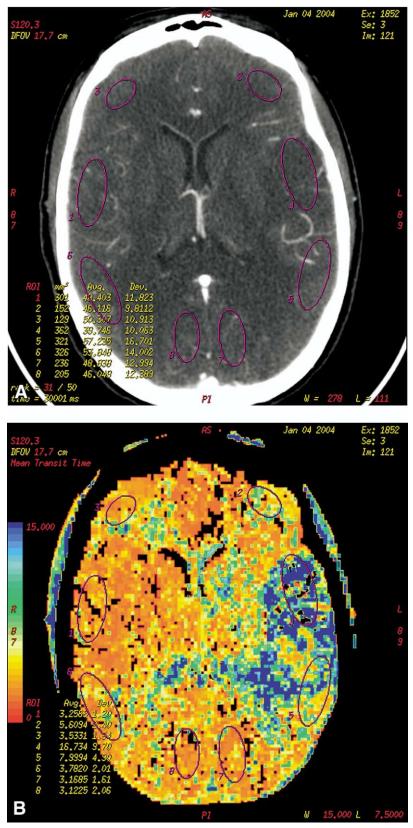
Contrast-enhanced CT of the brain with brain perfusion following saline flush. Axial source image with ROI placement (A) and color-coded perfusion map (B). Adding saline to the injection protocol has the potential to generate a more compact and defined bolus, which facilitates mathematical derivation of perfusion parameters. (Color version of figure is available online.)
